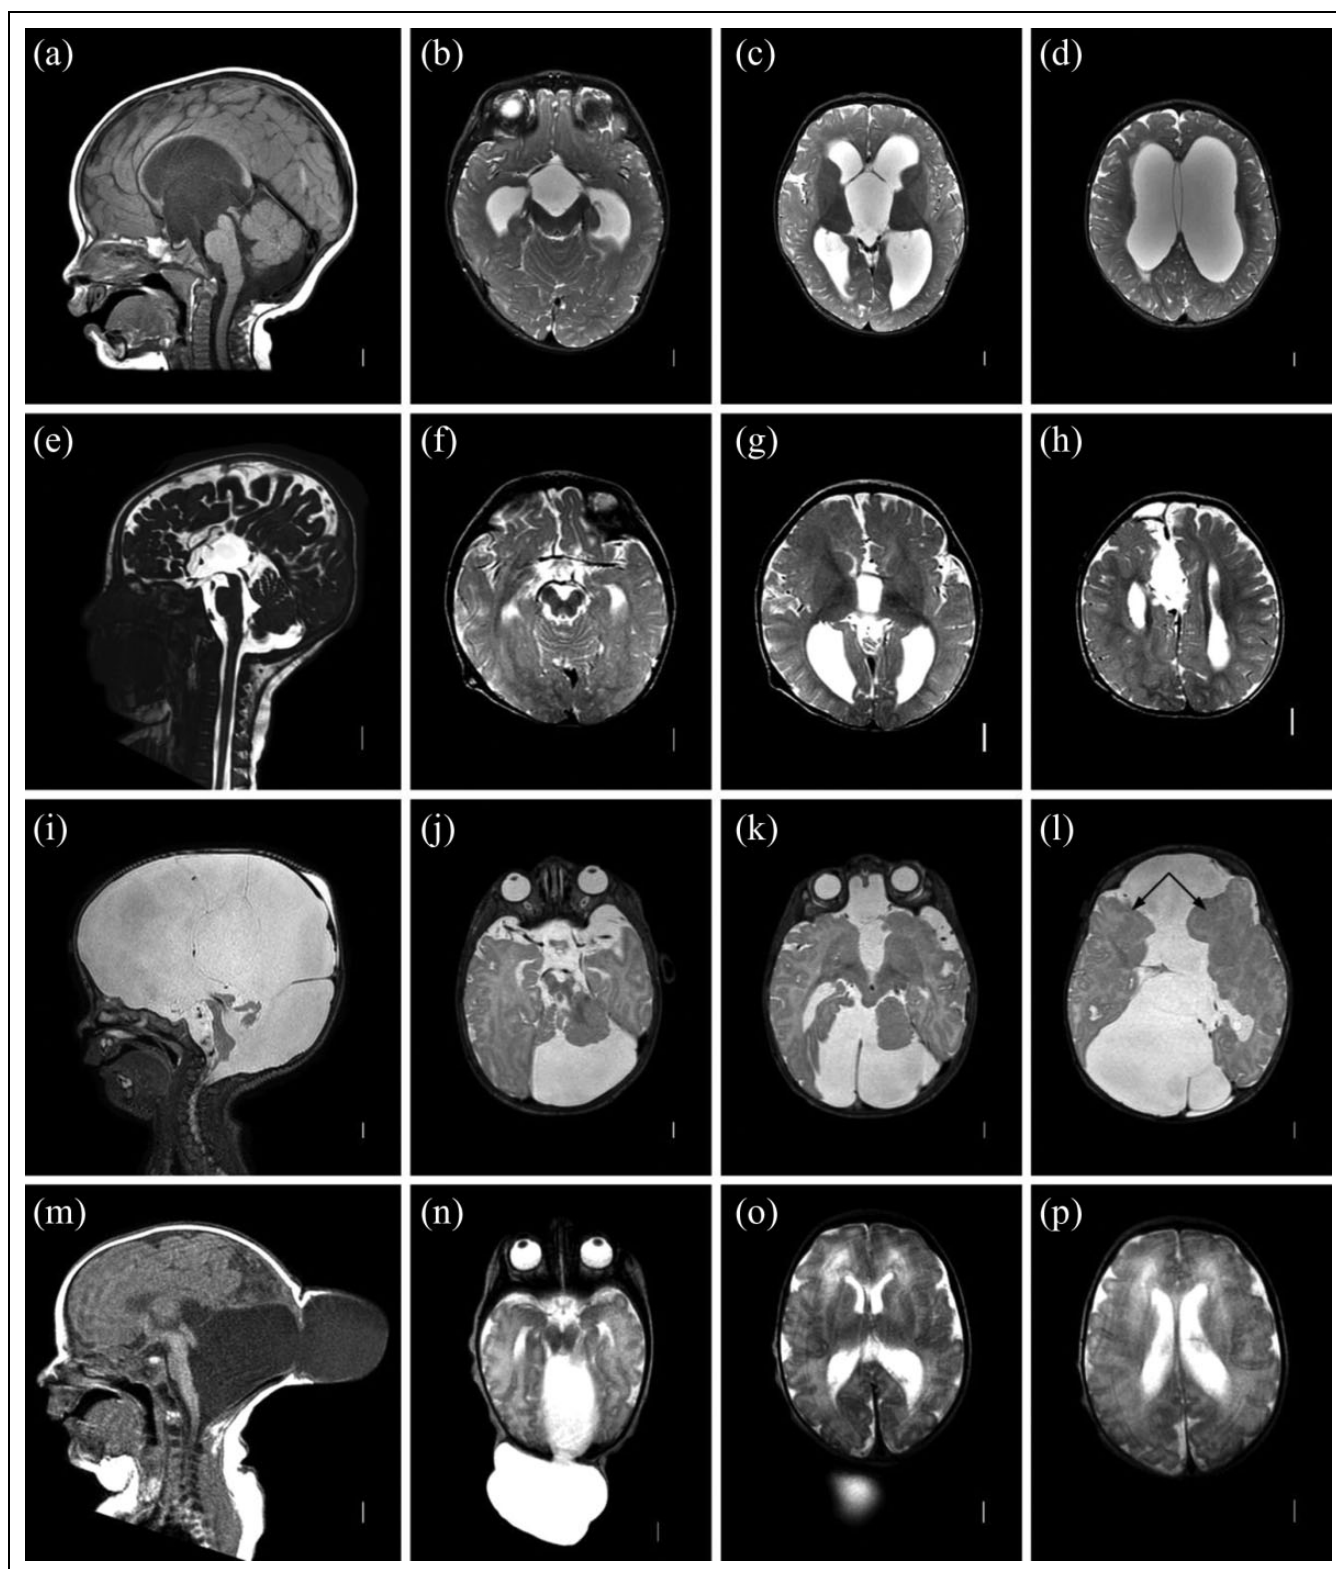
Cysts and cephaloceles. (A-D) Third ventricular cyst. Sagittal T1 (A) and axial T2 (B-D) MRI images demonstrating small, obstructive cyst with lack of additional brain malformations or cortical dysplasia. (E-H) Interhemispheric cyst. Sagittal constructive interference in steady state and axial T2 images showing interhemispheric cyst with absent corpus callosum. (I-L) Complex cystic malformation. Sagittal (I) and axial (J-L) T2 images demonstrating brainstem hypoplasia and extensive infolded, dysplastic cerebral hemispheres (L, arrows). (M-P) Encephalocele. Sagittal T1 images (M) showing cephalocele, with fluid collection in continuity with posterior fossa. Axial T2 images (N-P) demonstrating relatively normal-appearing cerebral hemispheres.
